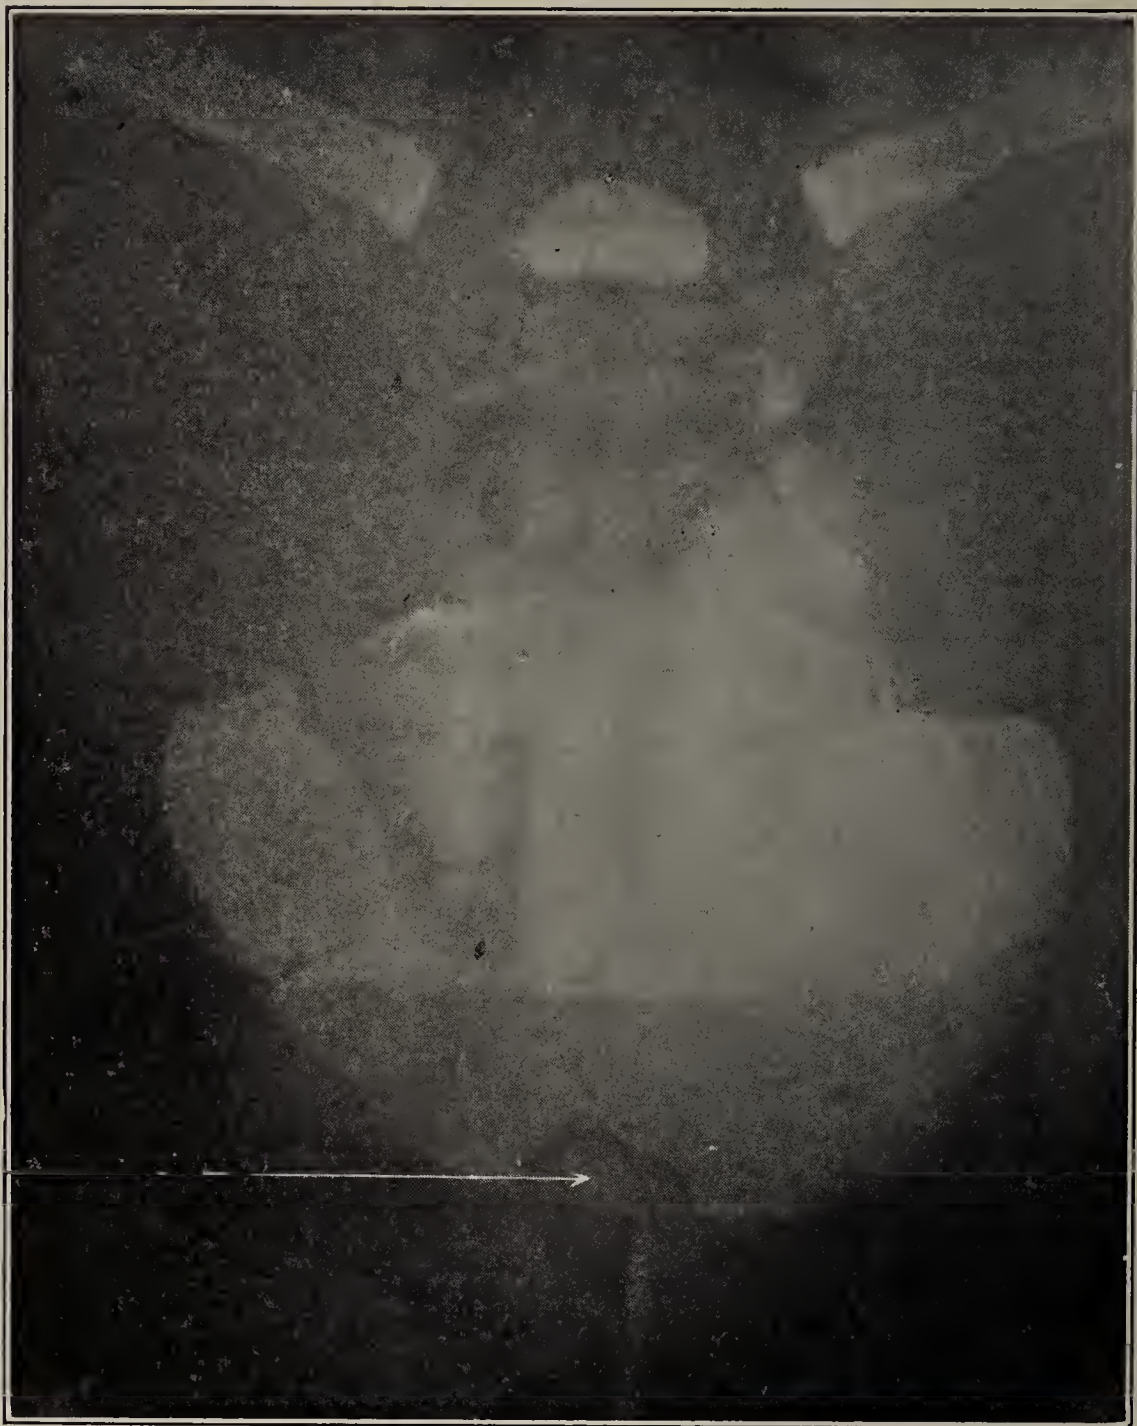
A.—RADIOGRAPH OF PROSTATIC CALCULUS. *S* shows the stone. (Author's case.)
